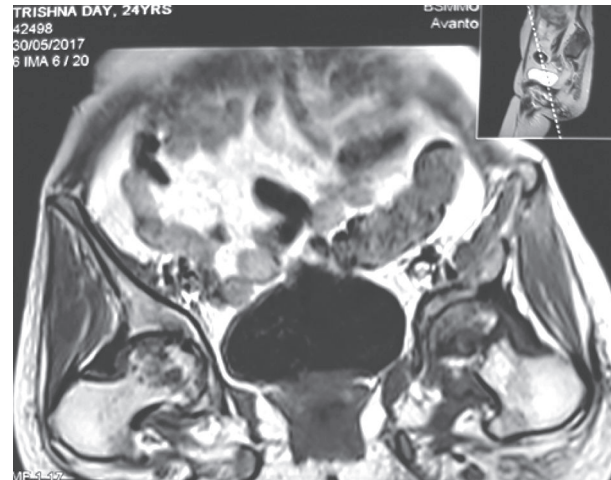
MRI of both hip and sacroiliac joints revealed mild flattening of heads of both femur, T2WI fat suppression and STIR- mixed signal changes seen in femoral head of both sides with reduction of joint space of both hip joints
